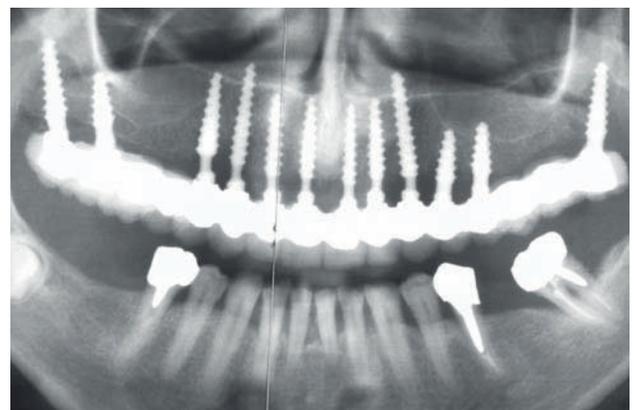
Control radiograph of the cemented bridge.
